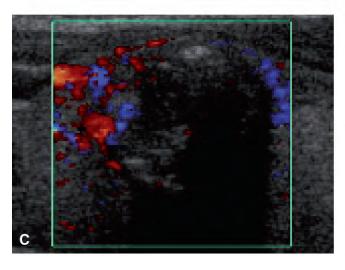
Ultrasound of a colloid nodule in the left lobe. A, Transverse, 13 x 14 mm. B, Longitudinal, sagittal diameter: 15 mm. C, Color Doppler, longitudinal.
